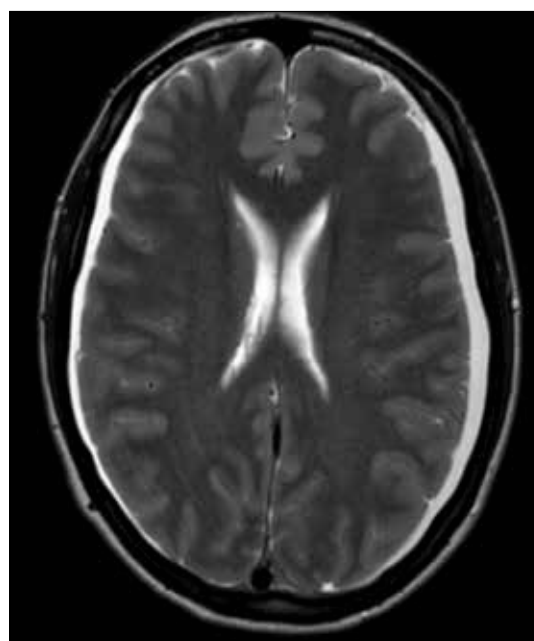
Axial MRI T2 of Mrs B showing bilateral hyperintense subdural collections.
